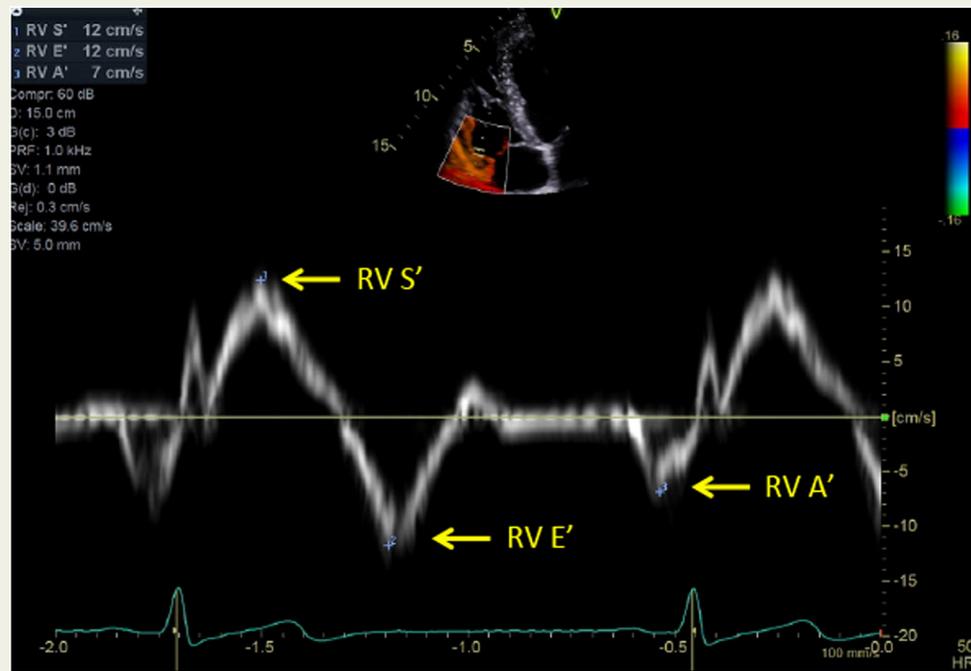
Measurement of tricuspid annular motion using Doppler tissue imaging. The key parameter of systolic function measured is peak systolic velocity (RV S').
